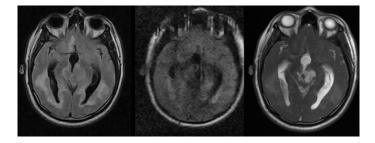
Axial section of brain magnetic resonance with FLAIR sequence, diffusion, and FIESTA sequence.
